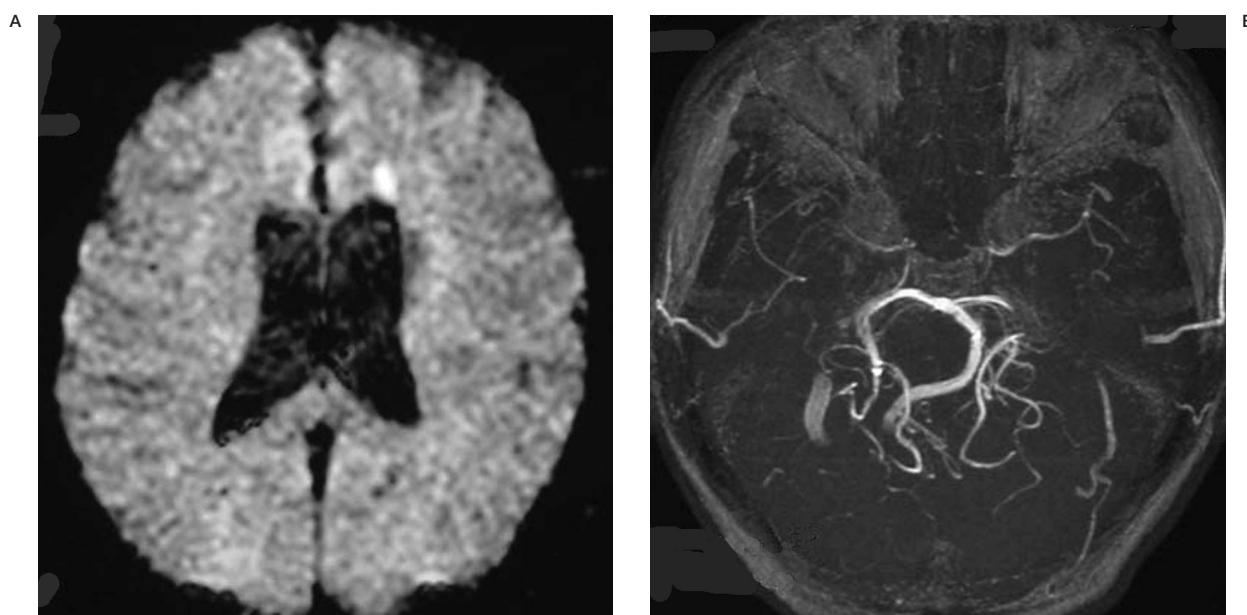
A diffusion-weighted MRI scan (A) shows that diffusion is restricted in the left frontal white matter. MRA (B) revealed bilateral internal carotid artery occlusion.
